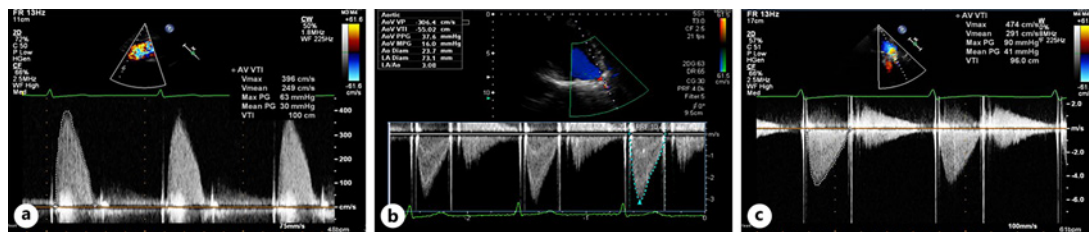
Changes on echocardiography. A Preoperative transthoracic echocardiography shows severe aortic stenosis ($AV_{max} = 3.96$ m/s). B Postoperative transthoracic echocardiography reveals improved aortic stenosis ($AV_{max} = 3.06$ m/s). C Transthoracic echocardiography shows exacerbation of aortic stenosis ($AV_{max} = 4.74$ m/s).
